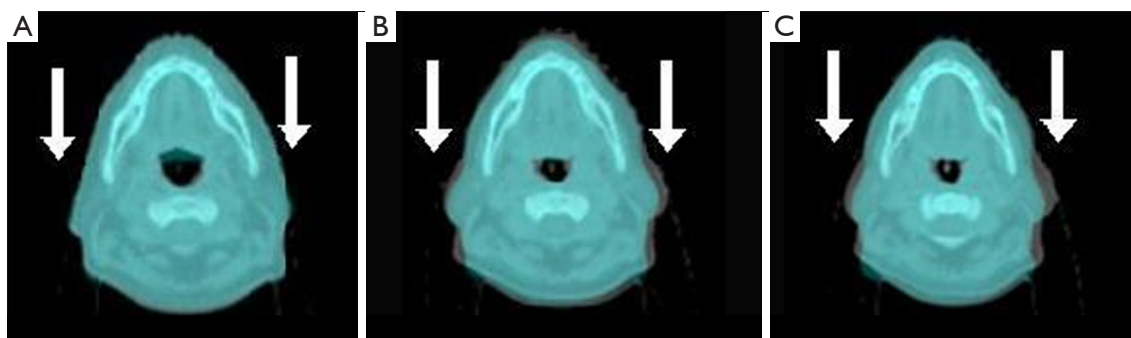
The change of the treatment volume during the treatment course for case 1 (registration of kVCT and MVCT images). The kVCT image is shown in gray and the MVCT image is shown in blue. (A) First plans (CT1); (B) before replanning CT2; (C) before replanning CT3. The arrows indicate the external volume change. kVCT, kilovoltage computed tomography; MVCT, megavoltage computed tomography.
